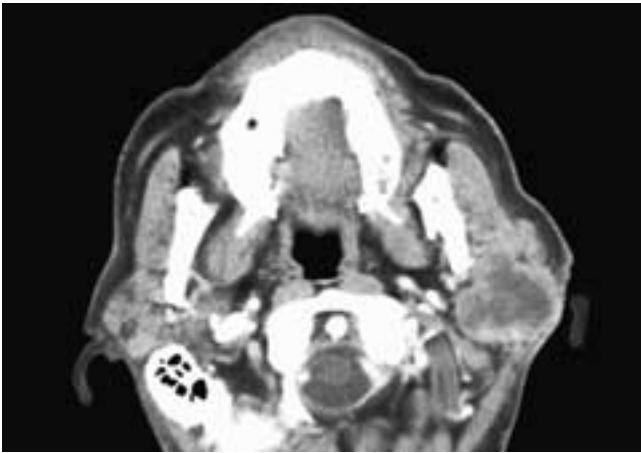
Axial contrast-enhanced CT scan shows a necrotic, ill-defined mass in the left parotid gland. This patient had an adenocarcinoma.
